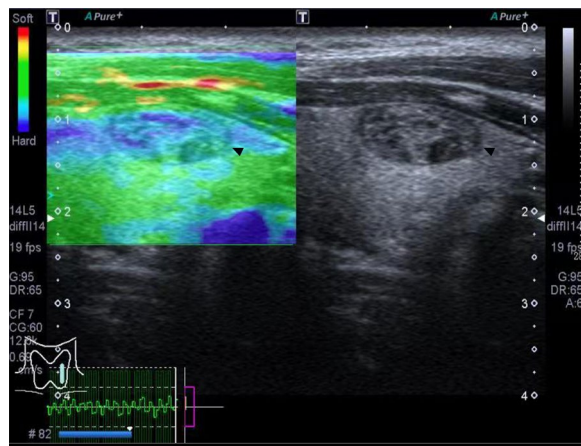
Thyroid nodule showed ES of 2. A 37-year-old male came to hospital for a follow-up visit of thyroid. Ultrasound image showed thyroid nodule exhibited nearly entire green with little blue was scored as 2 (marked with a black triangle). ES=elasticity score
